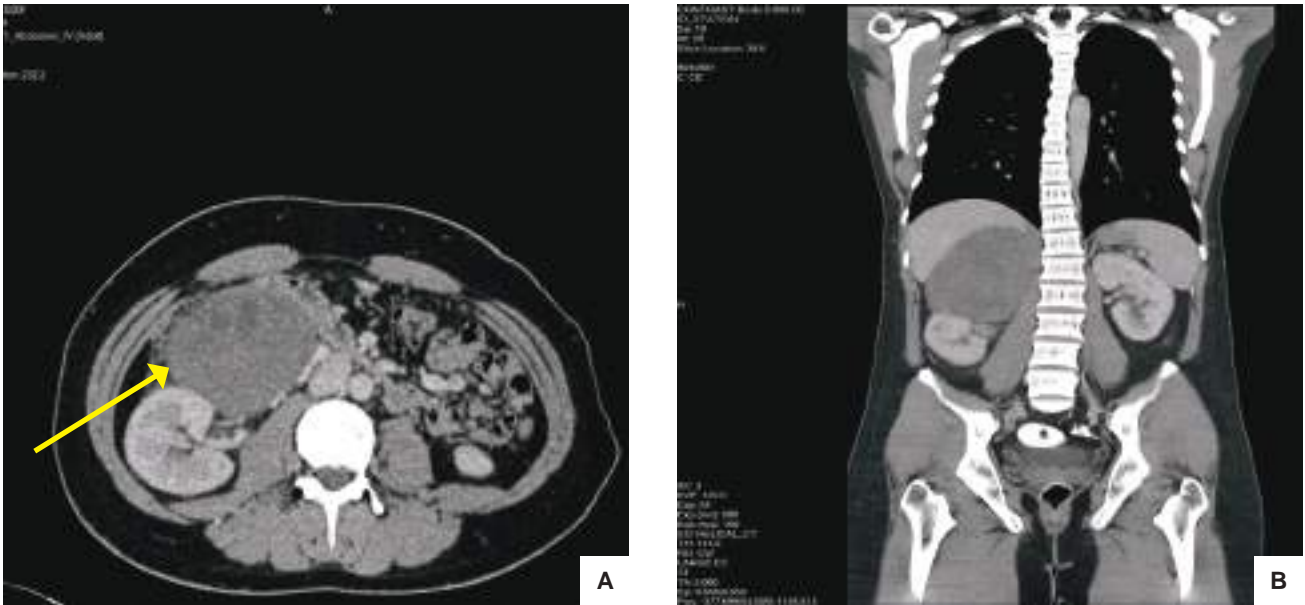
(A) Suprarenal mass with hypodense areas displacing the right kidney postero-inferiorly (CT Abdomen axial view); (B) CT Abdomen (coronal view).
